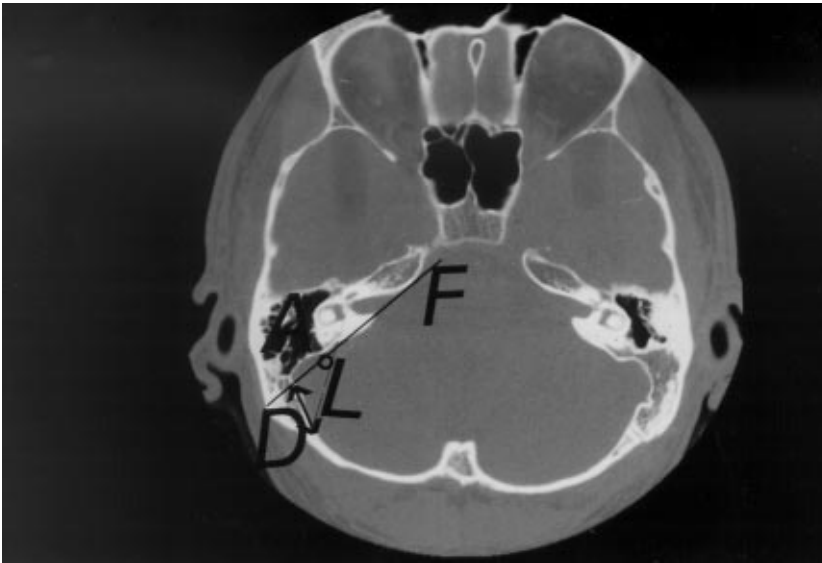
CT scan of the right temporal bone showing the distance D, line L, line F and angle A.
